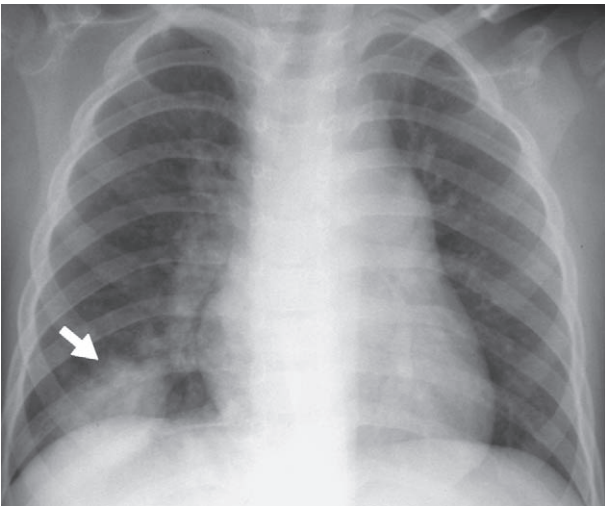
A 6 year-old boy presented with a 3 day history of fever and cough. Frontal chest radiograph shows a round mass-like lesion (arrow) in the right lower lobe.
